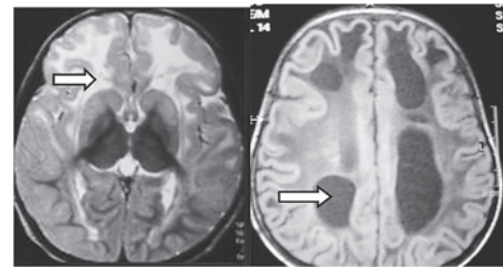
Alexander disease Axial T2 MR showing frontal white matter involvement b. Axial FLAIR showing cysts in the white matter
